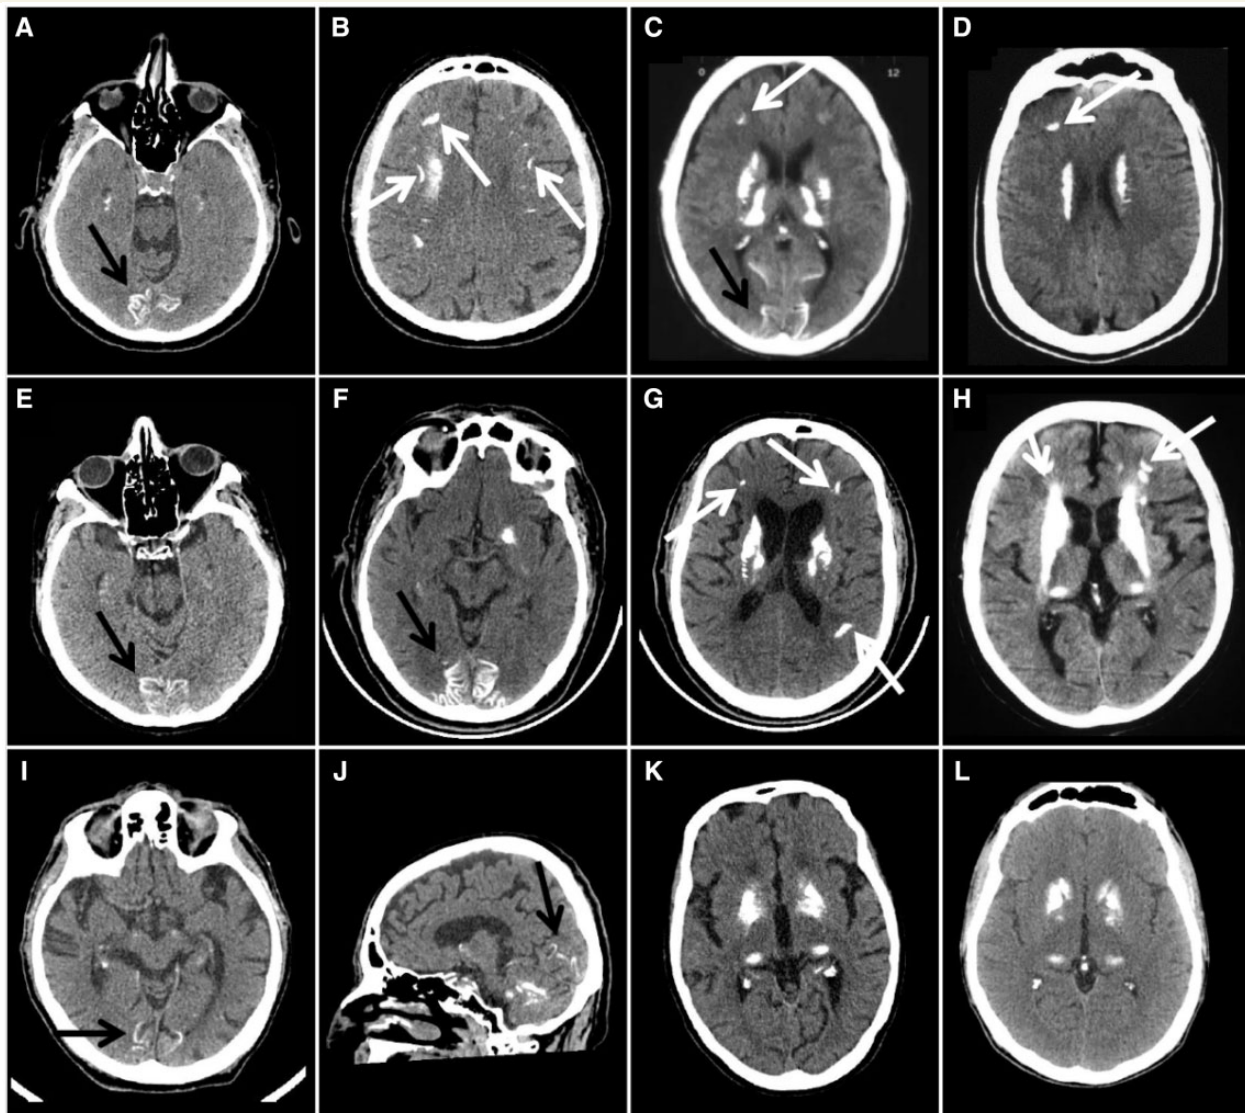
Cortical calcifications on the CT scans of the patients with *SLC20A2* mutations, mainly occipital (black arrows), and/or in the depth of the sulci (white arrows): Patient 1, Family 752 (A and B); Patient 2, Family 752 (C); Patient 1, Family 1038 (D); Case 1352 (E); Case 485 (F and G); Case 424 (H); Case 413 (I and J). Absence of cortical calcification in two *PDGFRB* patients (K and L, Family 870) despite severe calcification of the basal ganglia (severe calcification of both lenticular nuclei, confluent with severe calcification of both caudate nuclei (upstream of these slides), in K and L, and severe calcification of both thalami in K, faint in L).
